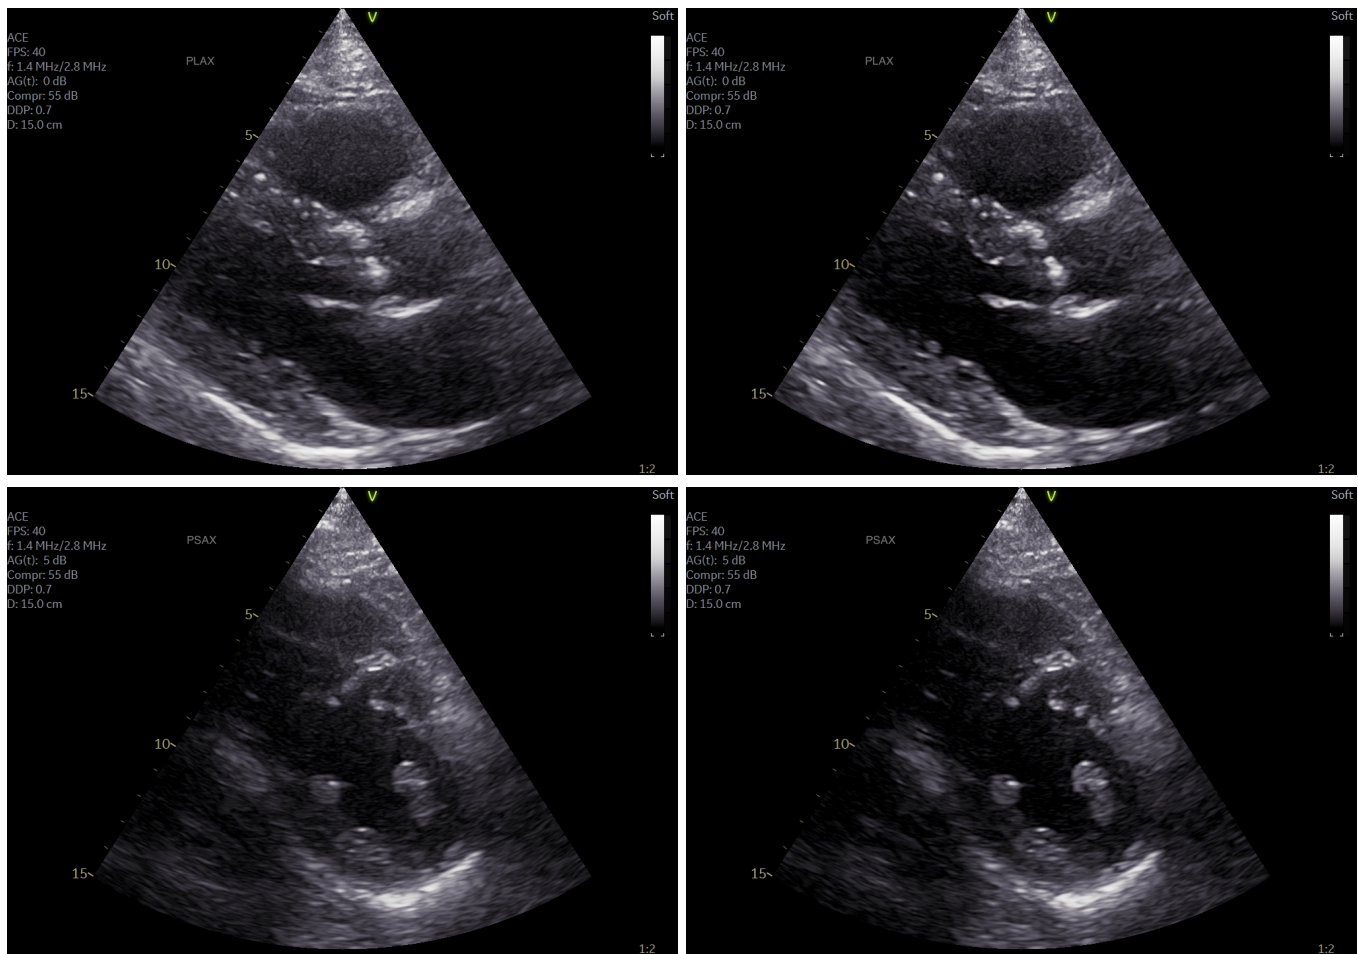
Case example 1. Parasternal views from patient 10. Standard image to the left and aberration corrected image to the right. Top row PLAX view, and bottom row PSAX views.
